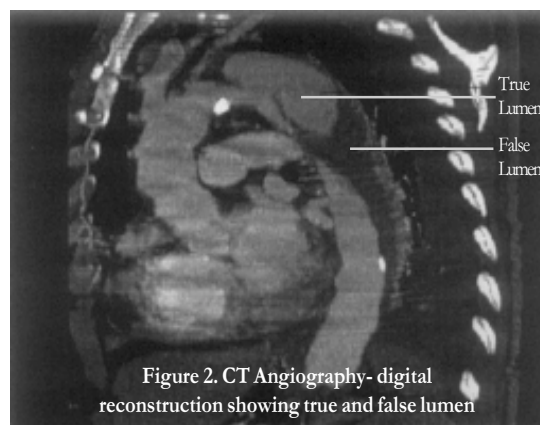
CT Angiography- digital reconstruction showing true and false lumen
